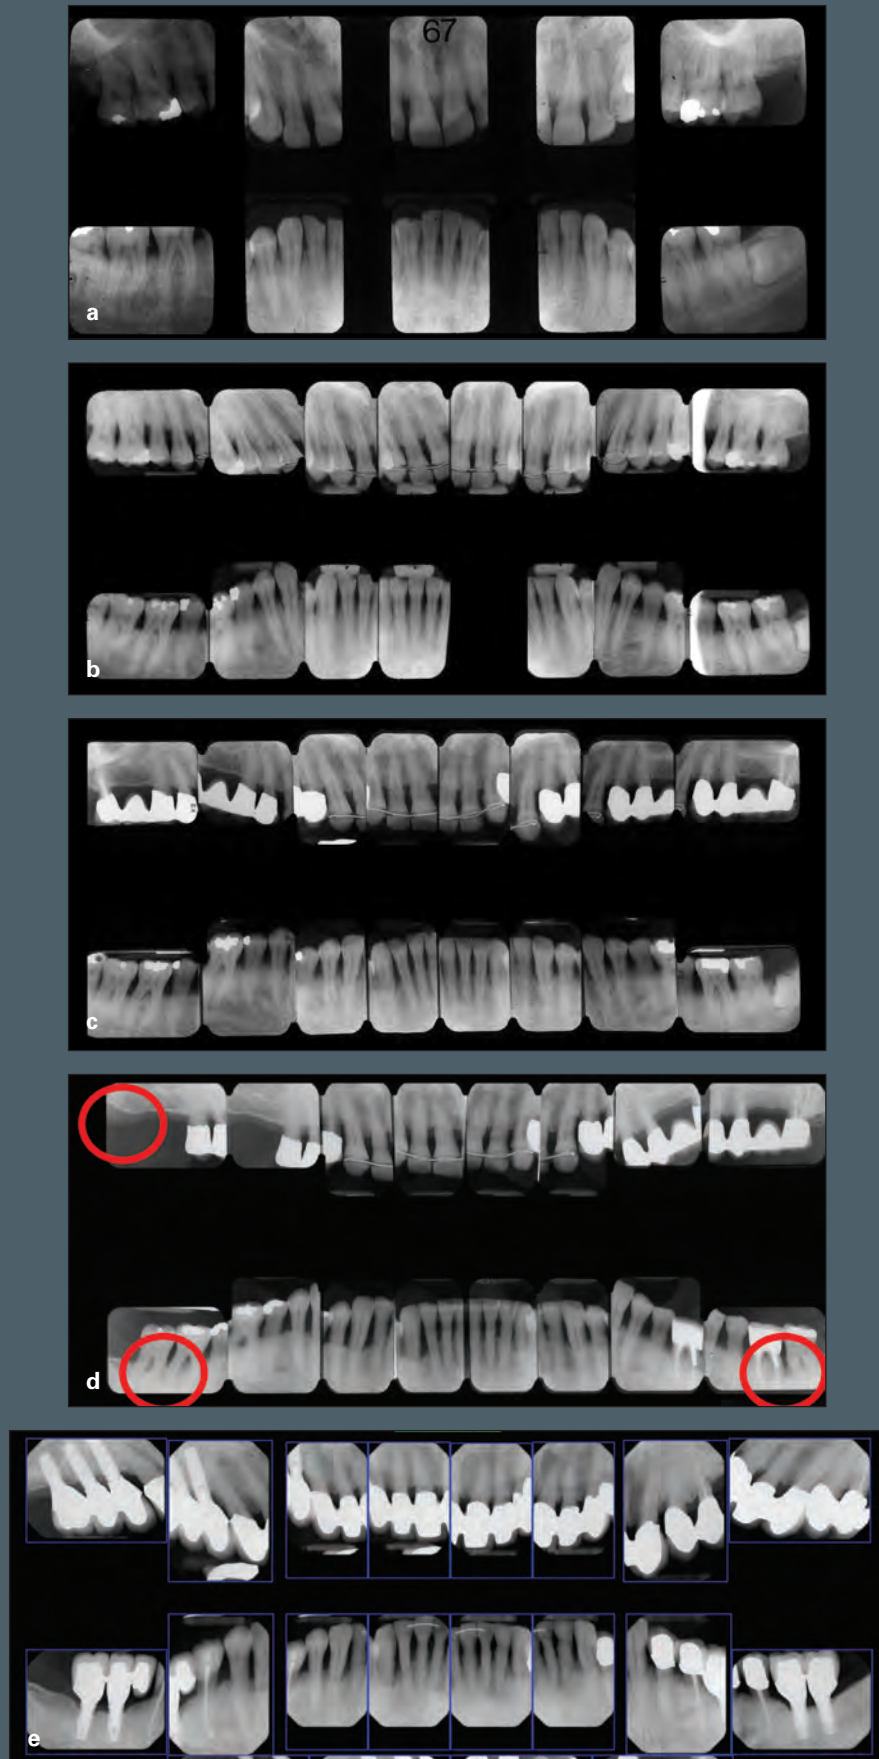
(a and b) Before and after radiographic surveys of a patient clearly susceptible to inflammatory periodontal disease. (c) A 13-year radiographic survey demonstrating the replacement of the maxillary first molars with fixed restorative dentistry. (d) The radiographic survey after 34 years. Red circles indicate loss of supporting bone. (e) A 50-year posttreatment radiographic survey. Treatment has been provided in an incremental fashion as additional areas required treatment.
